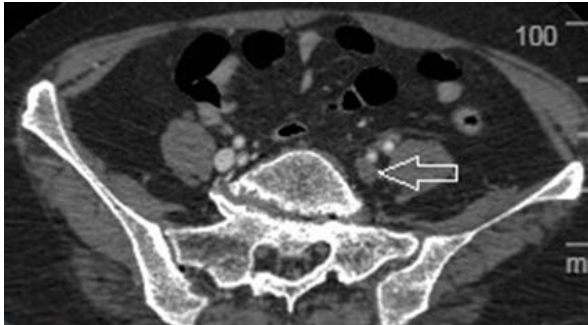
Computed tomography (CT) showing thrombus (Black Arrow) in distal part of inferior vena cava
